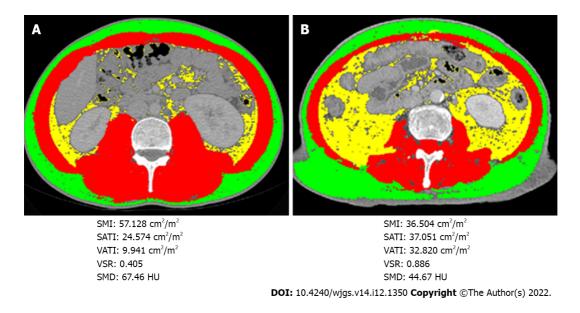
Selective representative computed tomography images with tag overlay at the third lumbar vertebra level from two individual patients with pancreatic cancer presenting with similar body mass index (21.45 kg/m<sup>2</sup> in patient A and 21.48 kg/m<sup>2</sup> in patient B). The red, yellow and green shadows indicate the skeletal muscle area (SMA), visceral adipose tissue area (VATA), and subcutaneous adipose tissue area (SATA), respectively. Skeletal muscle index, subcutaneous adipose tissue index and visceral adipose tissue index were calculated from SATA, VATA, and SMA divided by height in meters squared, respectively. The visceral to subcutaneous adipose tissue area ratio was calculated by dividing VATA by SATA. Skeletal muscle density indicates the mean computed tomography value (HU) of SMA. A: Body mass index (BMI): 21.45; B: BMI: 21.48. SMI: Skeletal muscle index; SATI: Subcutaneous adipose tissue index; VATI: Visceral adipose tissue index; VSR: Visceral to subcutaneous adipose tissue area ratio; SMD: Skeletal muscle density; HU: Hounsfield unit.
